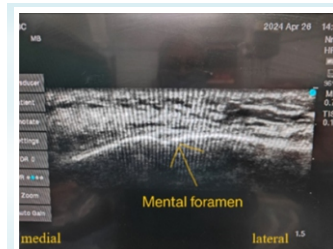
Ultrasound image of Mental foramen
